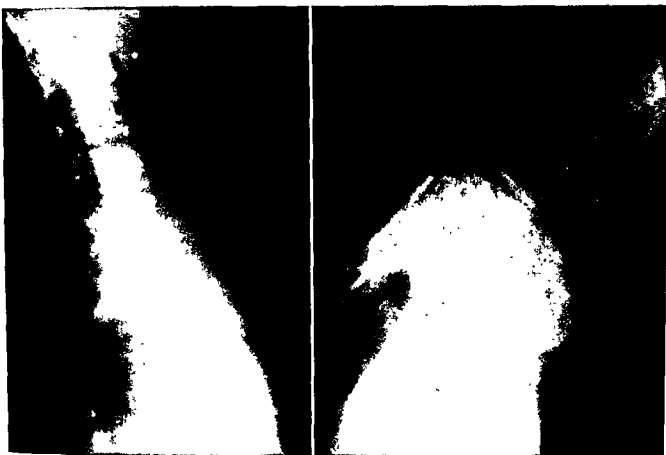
Roentgenograms 4 months after operation of spinal fusion shown in Figure 16. (Left) Lateral view with the spine in hyperextension. Note the increase in the thickness of this graft as compared with it 3 months previously in Figure 18. (Right) Flexion roentgenogram.
